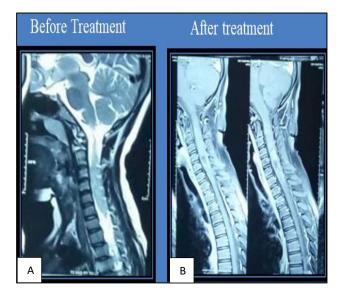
(A and B): Repeat MRI-suggested resolution of previous spinal lesion.
